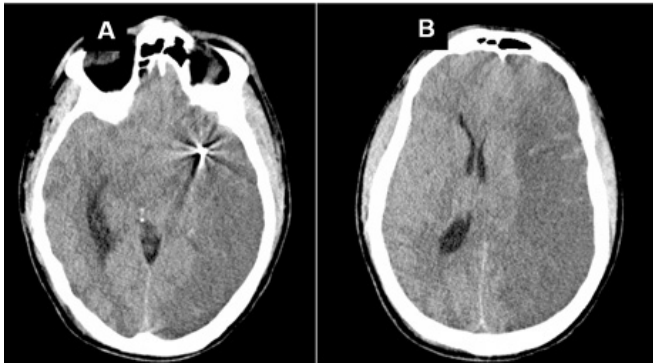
Computed tomography showing (A) pellet occlusion of left Middle Cerebral artery and (B) midline shift
